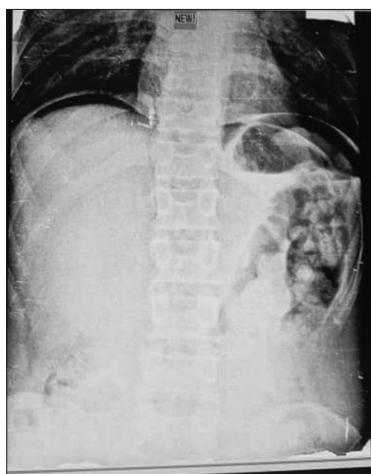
Erect chest X-ray showed air under diaphragm
